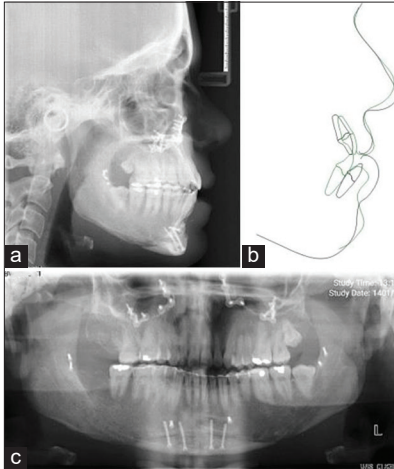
(a) Post-treatment lateral cephalometry. (b) Superimposition of pre-treatment (black) and post-treatment (green) cephalometric tracings. (c) Post-treatment panoramic radiograph.
